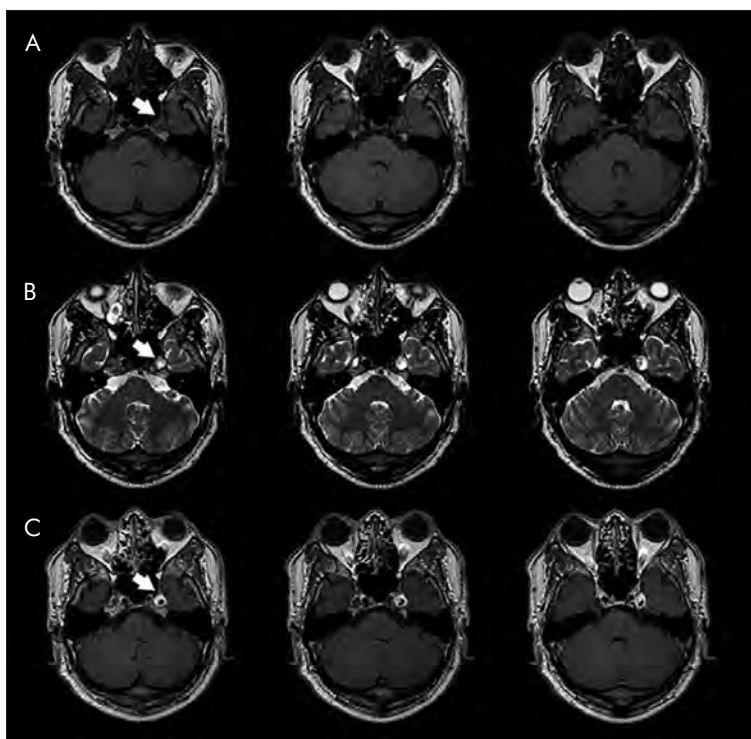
The patient's thin-slice, gadolinium-enhanced MRI, which revealed a 1.1 × 1.2 × 1.3 cm, well-defined, lobulated mass (arrow) compressing the trigeminal nerve in the left Meckel's cave (arrow). The lesion was slightly hypointense on T1-weighted imaging (A) with inhomogeneous high-signal intense on fat suppression T2-weighted imaging (B), and it showed intense enhancement with focal cystic change (C)
